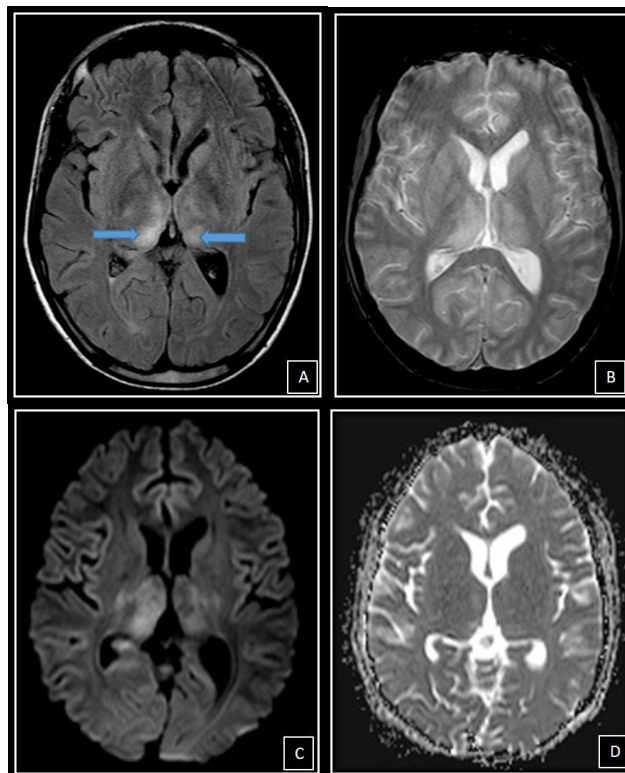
Japanese Encephalitis A: FLAIR axial B: FFE (GRE) axial C: DWI D: ADC A, B, C, D: FLAIR hyperintensities in both thalami (blue arrows), not showing blooming on FFE (GRE) or restricted diffusion.
